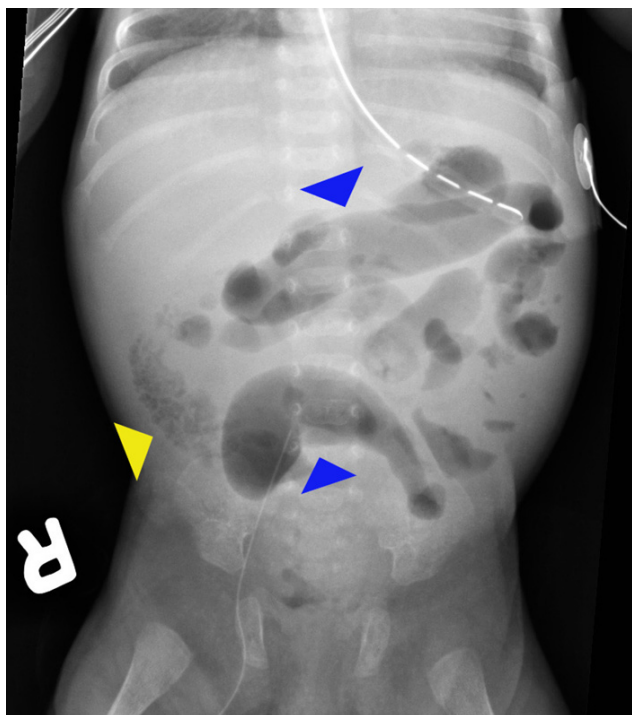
A supine abdominal radiograph of our patient on DOL 29
